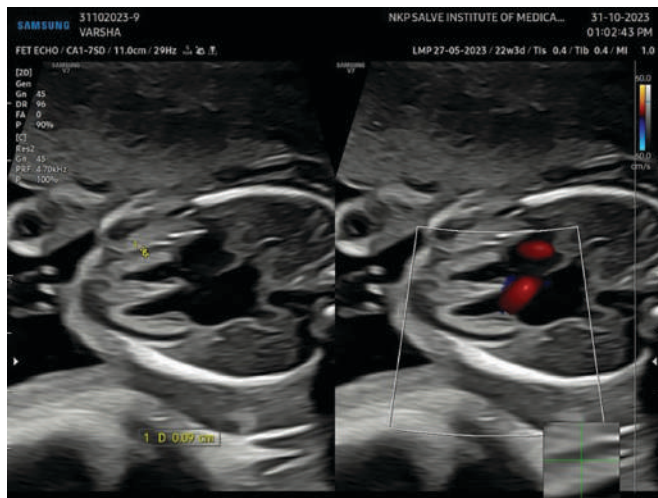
Image showing fetal epicardial fat thickness (fEFT) measurement in the standard four-chamber cardiac view at the midpoint of the right ventricular wall, with color Doppler aiding differentiation from pericardial fluid
